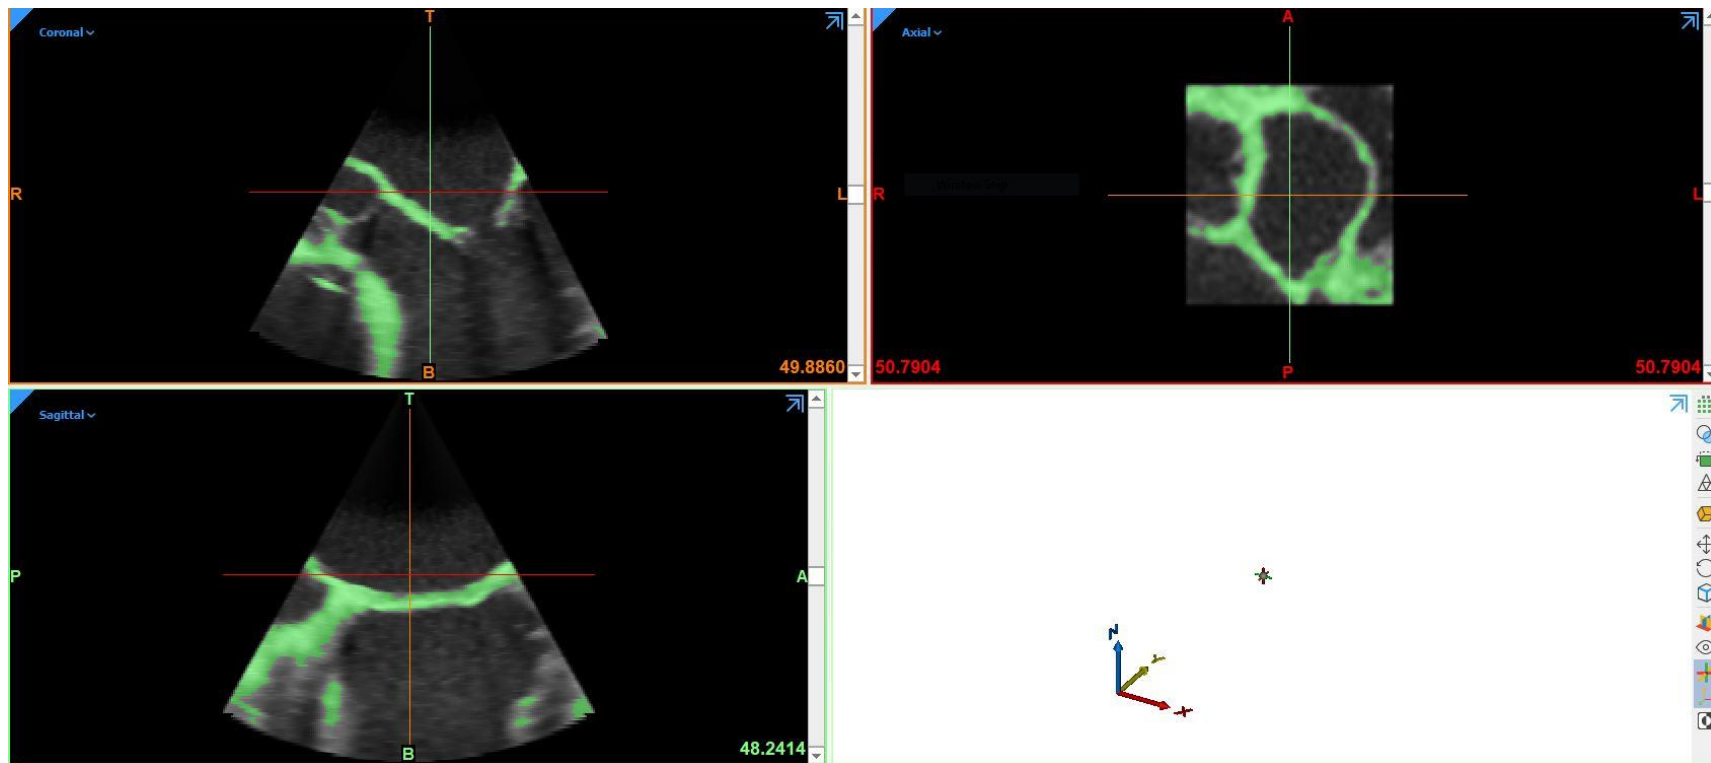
Thresholding of a mitral valve echocardiogram in Mimics software. Thresholded areas selected for inclusion in the design mask are shown in green.
